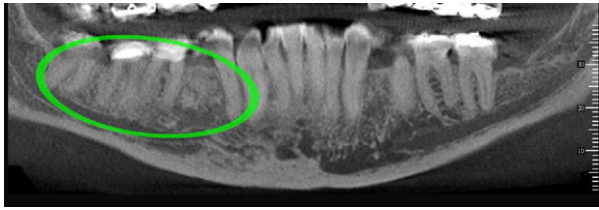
Case 8. CBCT scan showing focal osteosclerosis (circle) of alveolar margins and periodontal region similar to cases described by Arce et al.¹⁸
